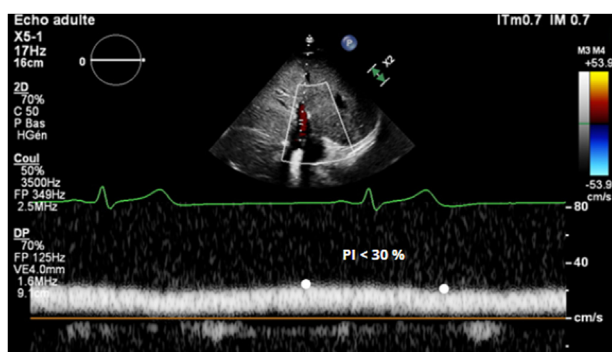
PW doppler of the portal vein at the hepatic hilum, showing a continuous positive flow at a barely varying magnitude, corresponding to a normal PI.
